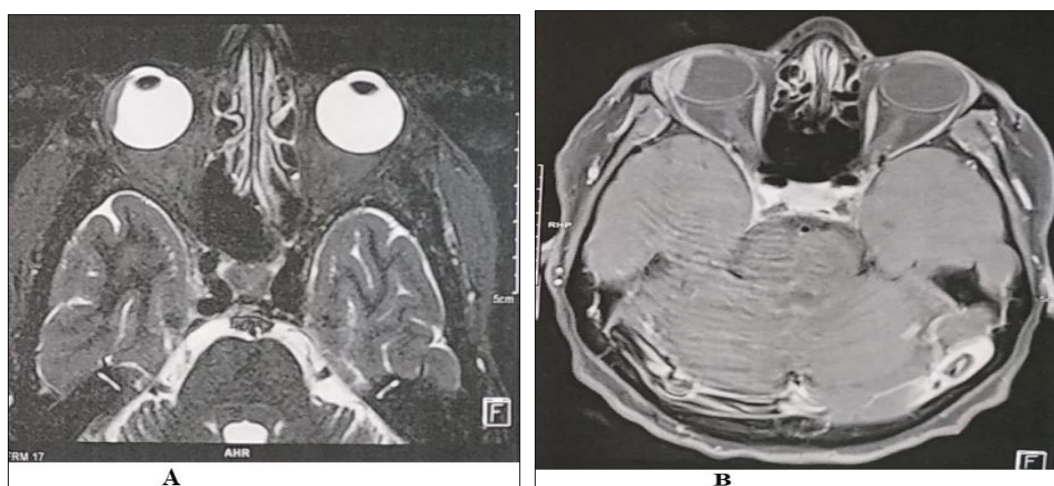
a,b: MRI showing a right temporal choroidal tissue infiltrate which homogeneous enhancement after contrast injection
